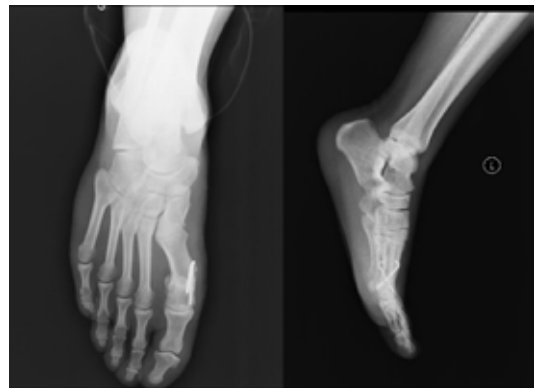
Postoperative radiographic images of a 22-year-old female patient with hallux valgus treated with Kirschner wires.
